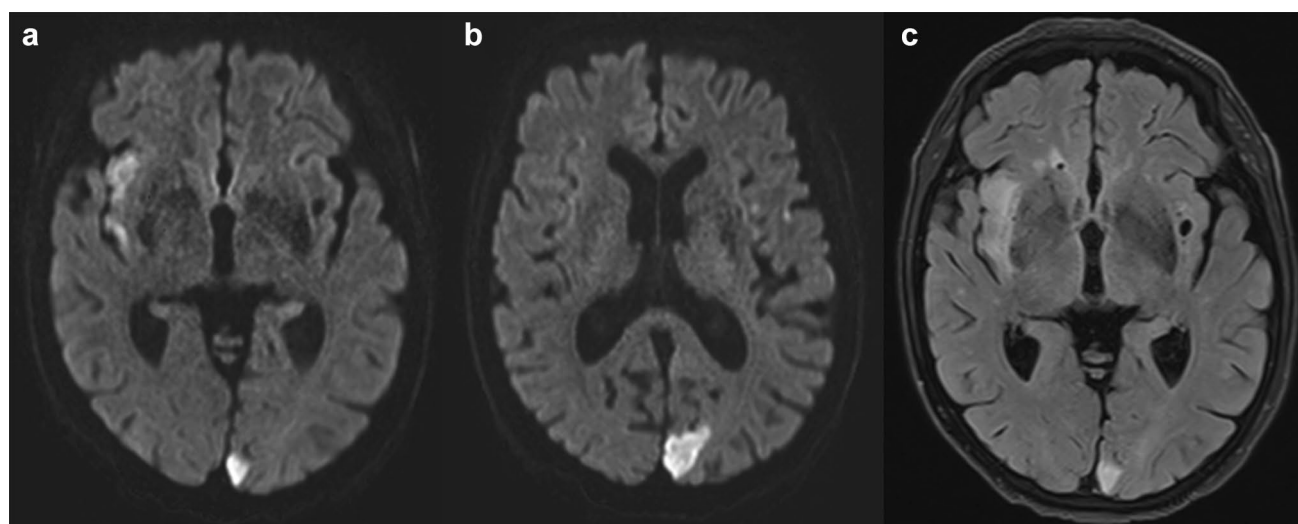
Brain MRI performed 6 days after the onset of stroke. Axial diffusion-weighted images (a, b) and FLAIR (c) revealed minimal acute infarcts of the left ACM territory, a more extensive right insular ischemic area, and a small left posterior cerebral artery territory infarct
